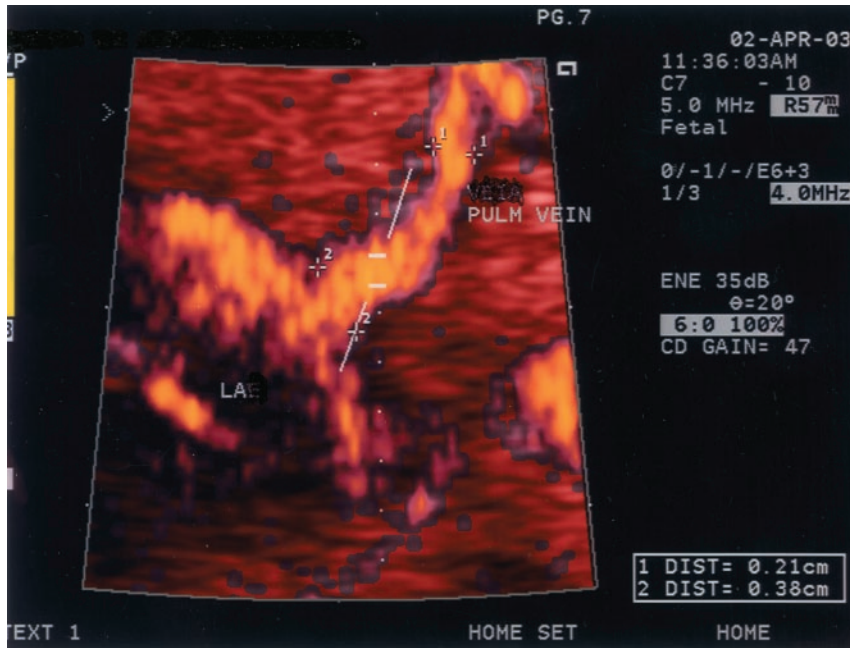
Right upper pulmonary (PULM) vein imaging in a 33-week fetus by 2D echocardiography enhanced by power Doppler. Notice progressive increase of vessel diameter toward left atrium (LA).
